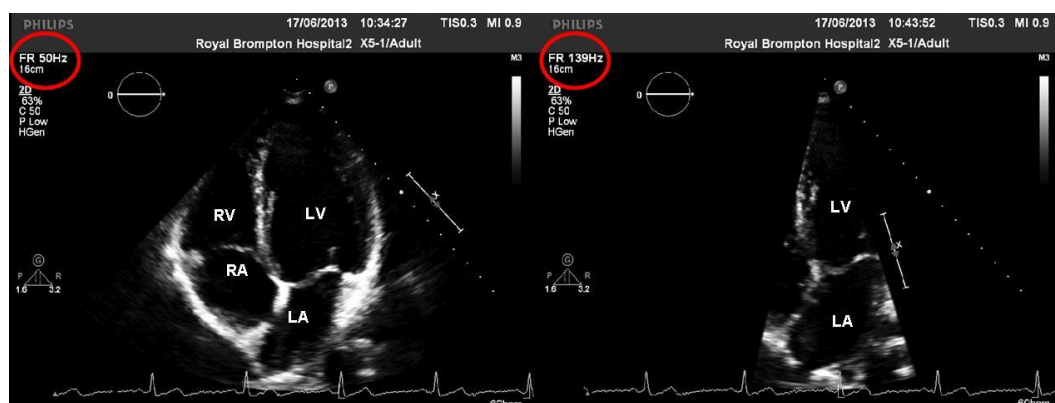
Apical 4-chamber views showing the effect of reducing the sector width on the ultrasound machine. In the image on the left, the sector width is optimal to view all four cardiac chambers. In the image on the right, the sector width has been reduced excessively so only part of the LV and LA are visible. Note that the frame rate has increased (circled in red) as a result of the reduction in sector width (for full explanation see text).
